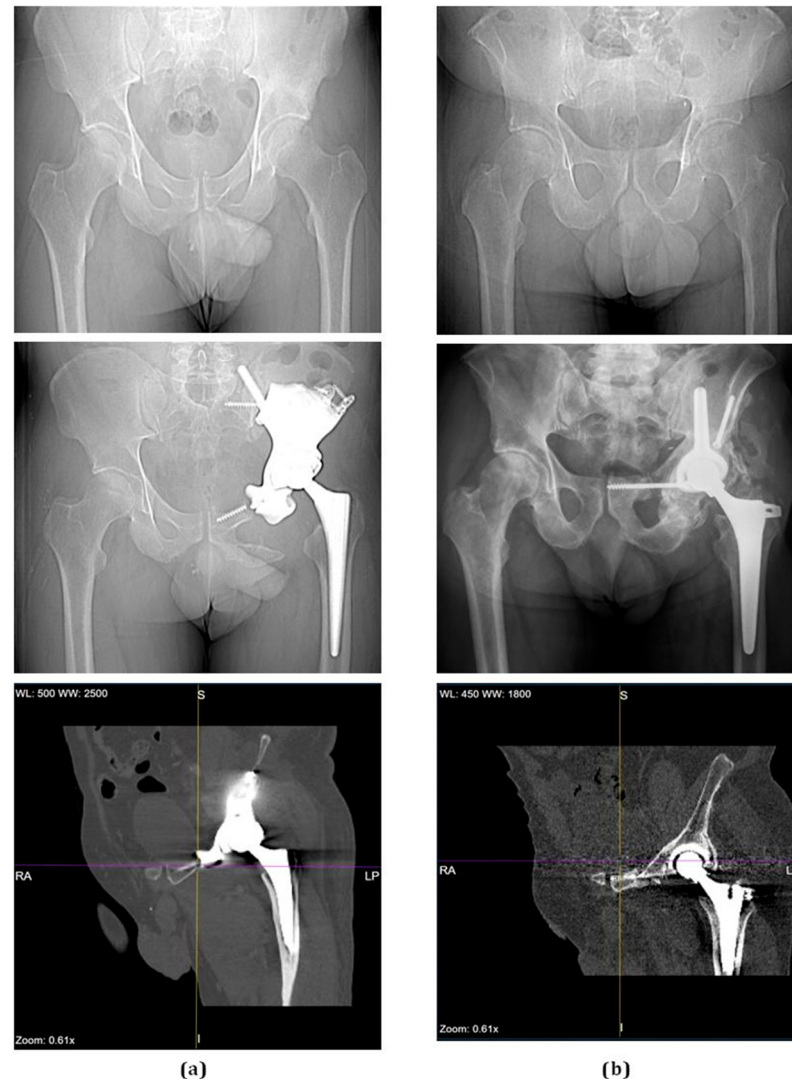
Radiological examination of two representative patients, one selected for a 3D-printed custom implant (a) and one for the bone graft implant (b). Pre-operative frontal radiograph (top images), post-operative frontal radiograph at 6 month follow-up (middle images), and CT scan (bottom images). Notice how the CT in (a) has a larger area of high signal intensity in the pelvis, which represents the massive pelvic implant compared to the CT in (b) with a smaller area of signal intensity representing the acetabular cup and bone graft in the pelvis.
